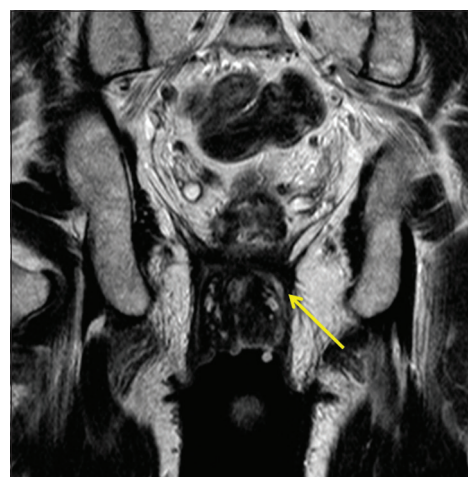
Coronal T2-weighted image shows a hyperintense trans-sphincteric tract, with its external opening in left perianal region, extending in left perianal region and crossing midline in infralevator region to the right side (yellow arrow)
